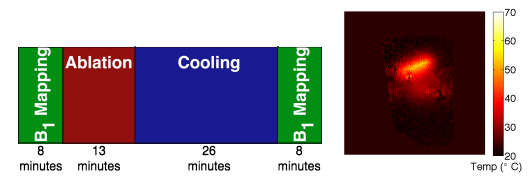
MRI ablation timing (left) and representative temperature image (right) for 64 MHz ablation. B1 maps are acquired before and after ablation. MRI temperature maps were acquired periodically during ablation and cooling, while electric impedance and fluoroptic thermal sensing can be monitored continuously.
